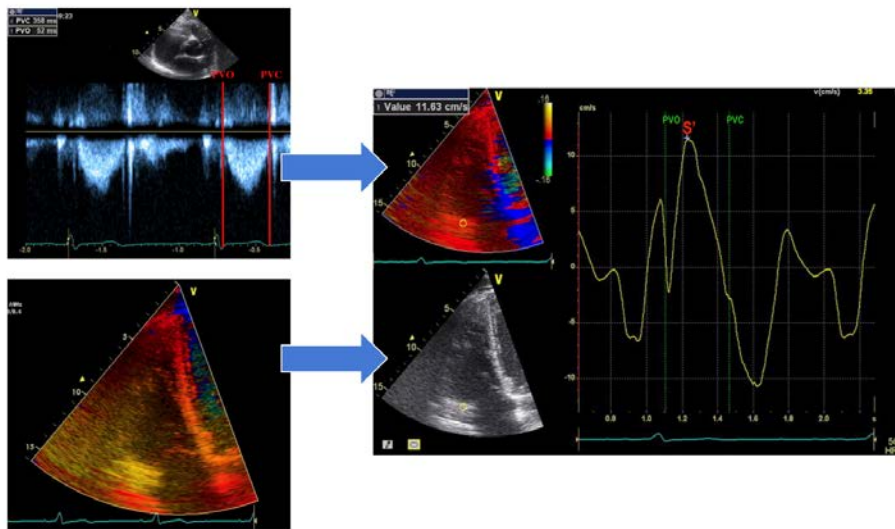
Measuring the tricuspid annular peak systolic tissue velocity using colour tissue velocity echocardiography imaging (RV CTDE S')
